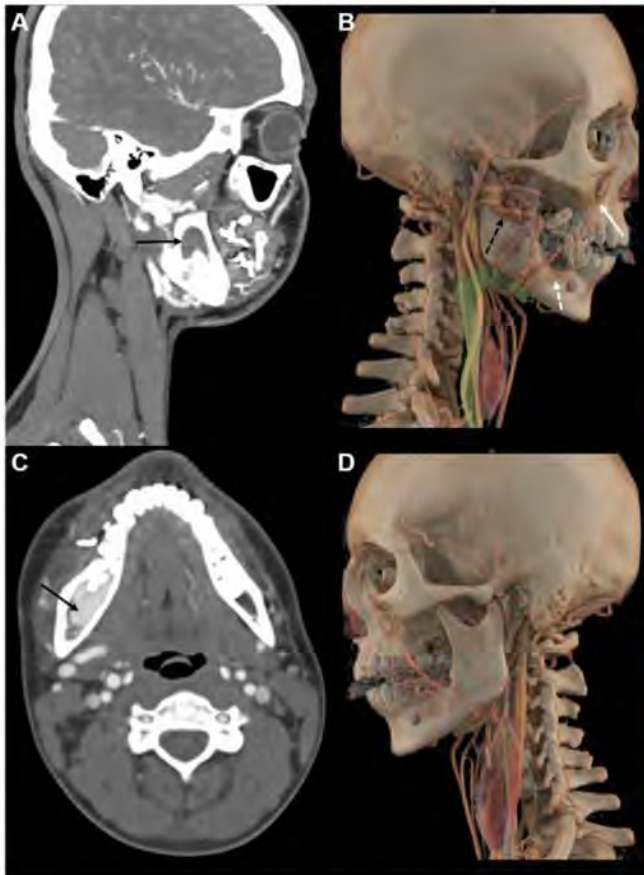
Axial Sagittal (A) and Coronal Axial (C) contrast enhanced CT of the mandible with corresponding 3D volume illumination rendered images (B, D), demonstrating an expansile lytic homogeneously intensely enhancing AVM (black solid arrows) in the right mandible extending from the angle to the roots of tooth #6. Dilated and tortuous inferior alveolar (black dashed arrow), angular (white solid arrow), and mental (white dashed arrow) arteries are present on the right side, and an enlarged facial vein emptying into a dilated internal jugular vein is highlighted in green. The left-sided 3D volume rendered image depicts normal appearing vasculature.
